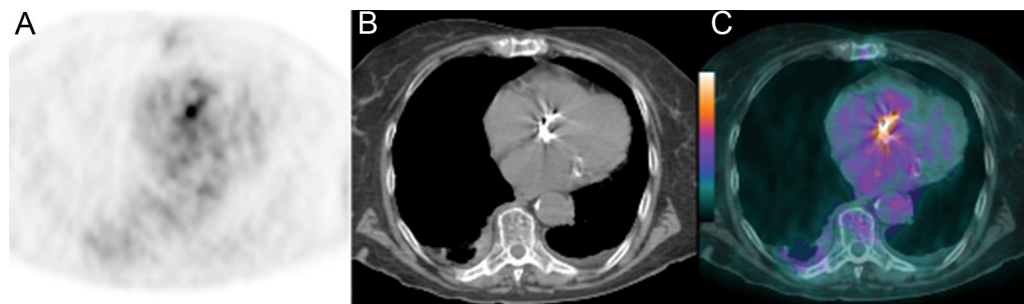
Transverse images from an 83-year-old woman with PVE: (A) ¹⁸F-FDG-PET-CT; (B) CT; (C) integrated ¹⁸F-FDG-PET-CT. High FDG uptake was observed at the level of the aortic prosthesis.
